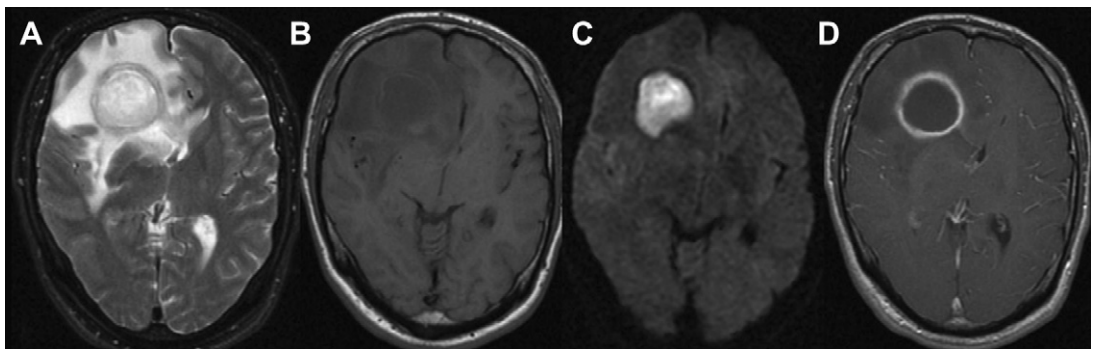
Cerebral abscess in a 46-year-old man who presented with seizures and fever. Axial T2WI (A) at the level of ventricles showing a heterogeneous intensity lesion with surrounding edema in right frontal region. The lesion is hypointense on T1WI (B), with peripheral enhancement on postcontrast T1WI (D). On DWI (C), the lesion shows restricted diffusion. Pus culture grew *Staphylococcus aureus*.
